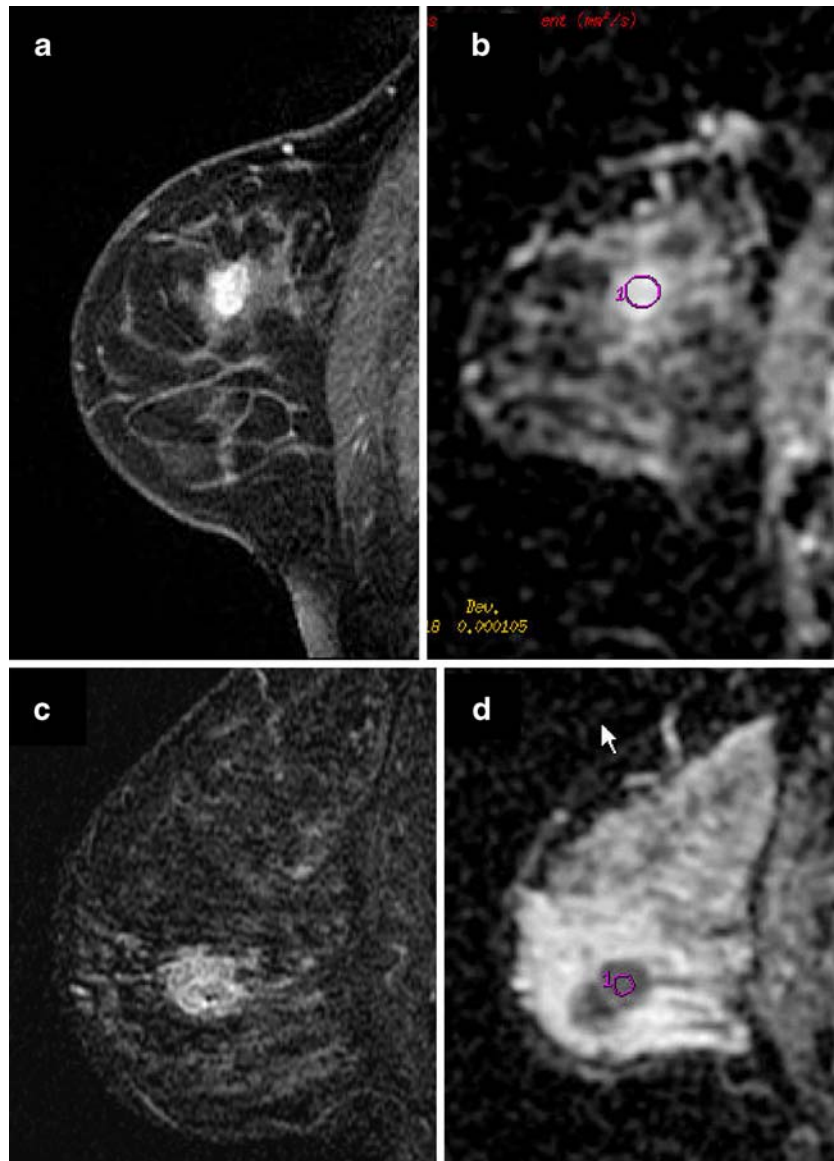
(a) Enhancing fibroadenoma in post-Gd image. (b) ADC map with ROI in place. The average ADC value was $2.07 \times 10^{-3} \text{ mm}^2/\text{s}$, well above the threshold of $1.2 \times 10^{-3} \text{ mm}^2/\text{s}$, below which we worry about malignancy. (c) Heterogeneously enhancing invasive ductal cancer. Note biopsy marking clip (tiny black focus) within the central inferior portion of the lesion. (d) ADC map with ROI in place. ADC was $0.91 \times 10^{-3} \text{ mm}^2/\text{s}$, highly suggestive of malignancy. Tumor morphology on ADC map appears different due to partial volume effects from thicker DWI slice (6 mm between slices vs. 3 mm for image in (c)). Note that titanium clip did not affect quality of ADC map.
